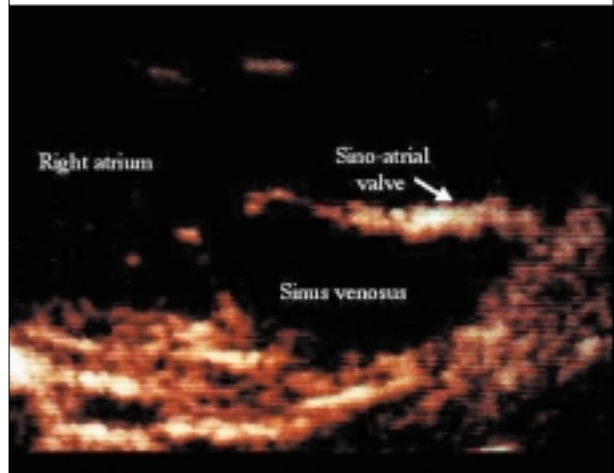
Two-dimensional echocardiogram. This right transatrial short-axis section shows the opening of the sinus venous into the right atrium and the anomalous sinoatrial valve (arrow).
